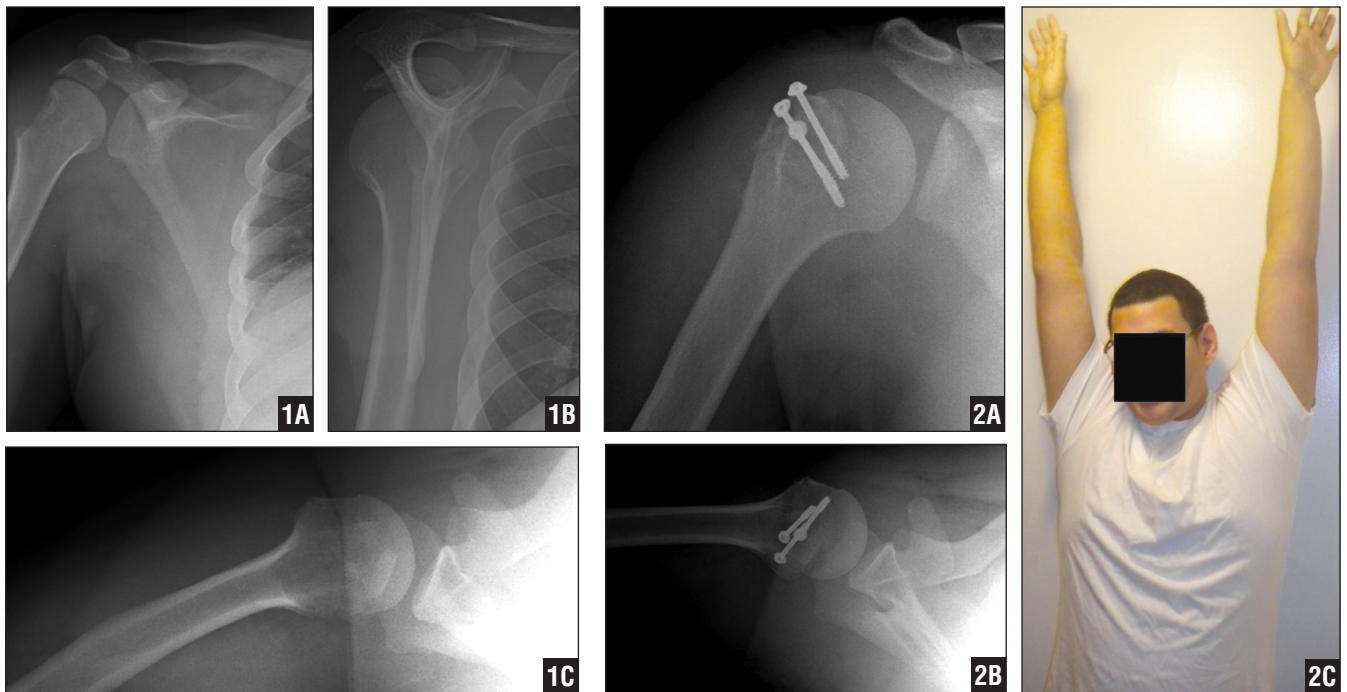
Preoperative anteroposterior (A), lateral (B), and axillary (C) radiographs of the right shoulder in an 18-year-old right-hand-dominant man showing a displaced isolated greater tuberosity fracture where the greater tuberosity fragment is unusually large, with 36 mm of superior displacement.
